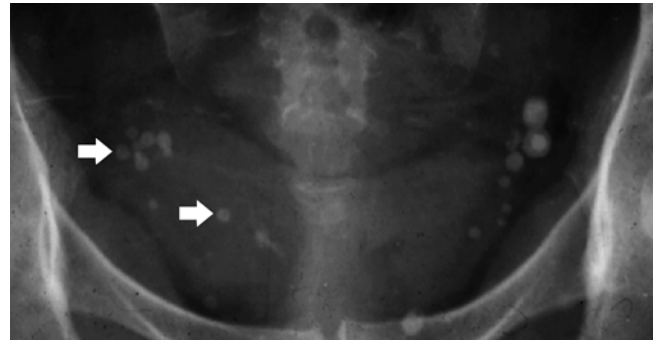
Plain abdomen radiography. Pelvic phleboliths appearing as multiple round or oval opacities with a central lucency (*arrows*), and lateral to the inferior portion of the sacrum
